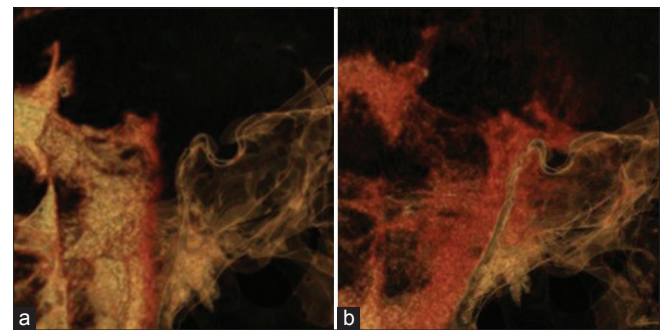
Sagittal reconstruction of MPR images obtained by high-resolution CT with intrathecal injection of contrast medium. (a) Thirty minutes after injection, contrast medium advances into the interpeduncular and prepontine cistern, but not into the sphenoid sinus. (b) One hour after injection, contrast medium is clearly shown entering into the sphenoid sinus through the bone defects at the clivus
